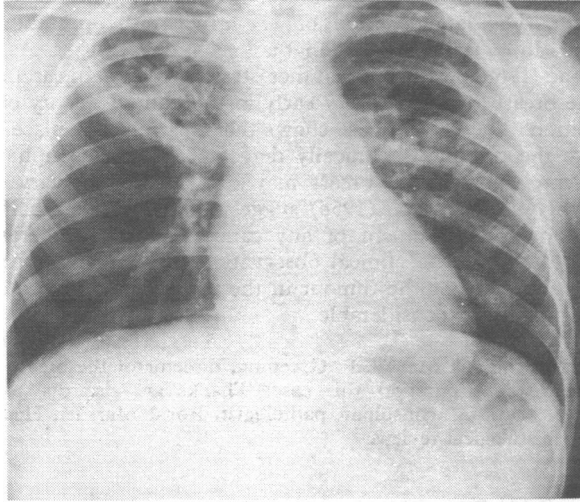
X-ray picture showing enlargement of cavities in left lung; opacities within cysts were suggestive of a mycetoma.
